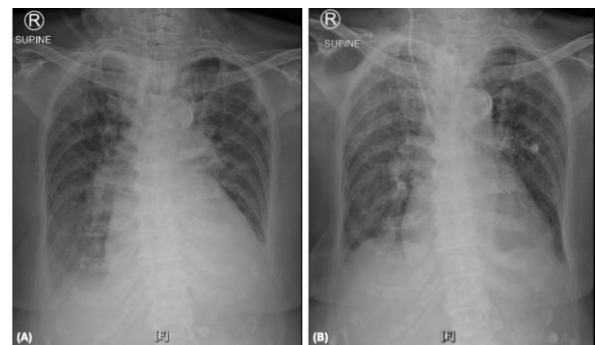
Serial chest radiographs in an elderly patient with severe pneumonia. (A) Initial chest radiograph showing bilateral pulmonary infiltrates. (B) Follow-up chest radiograph demonstrating improvement in pulmonary opacities after treatment.
